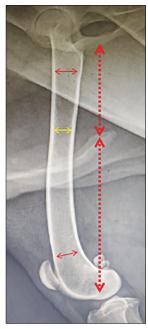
Radiograph showing various measurements.
